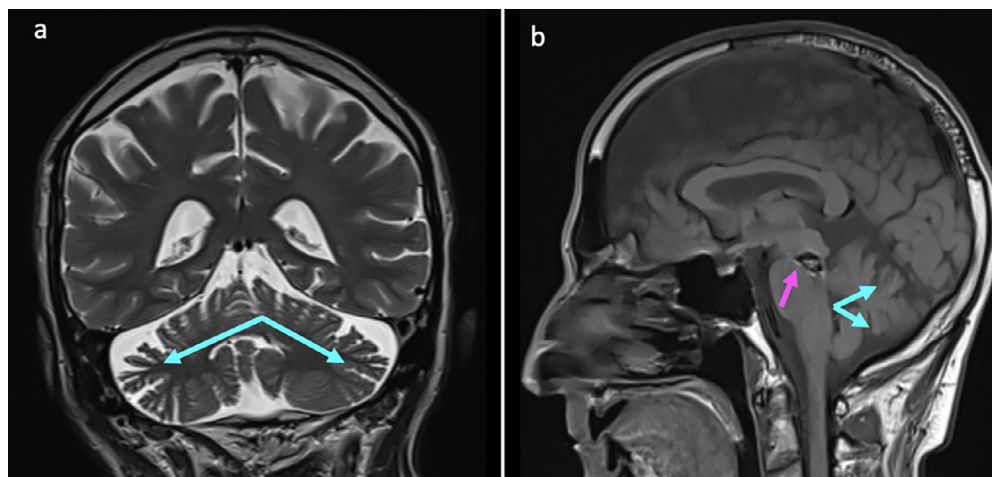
Cerebellar-MRI images on coronal T2-weighted (A) and sagittal T1-weighted (B) sections reveal an enlargement of the cerebellar cortical sulci (Blue arrows), corresponding to a cerebellar atrophy. Note the coronal section of the mesencephalic cavernoma (Pink arrow).
